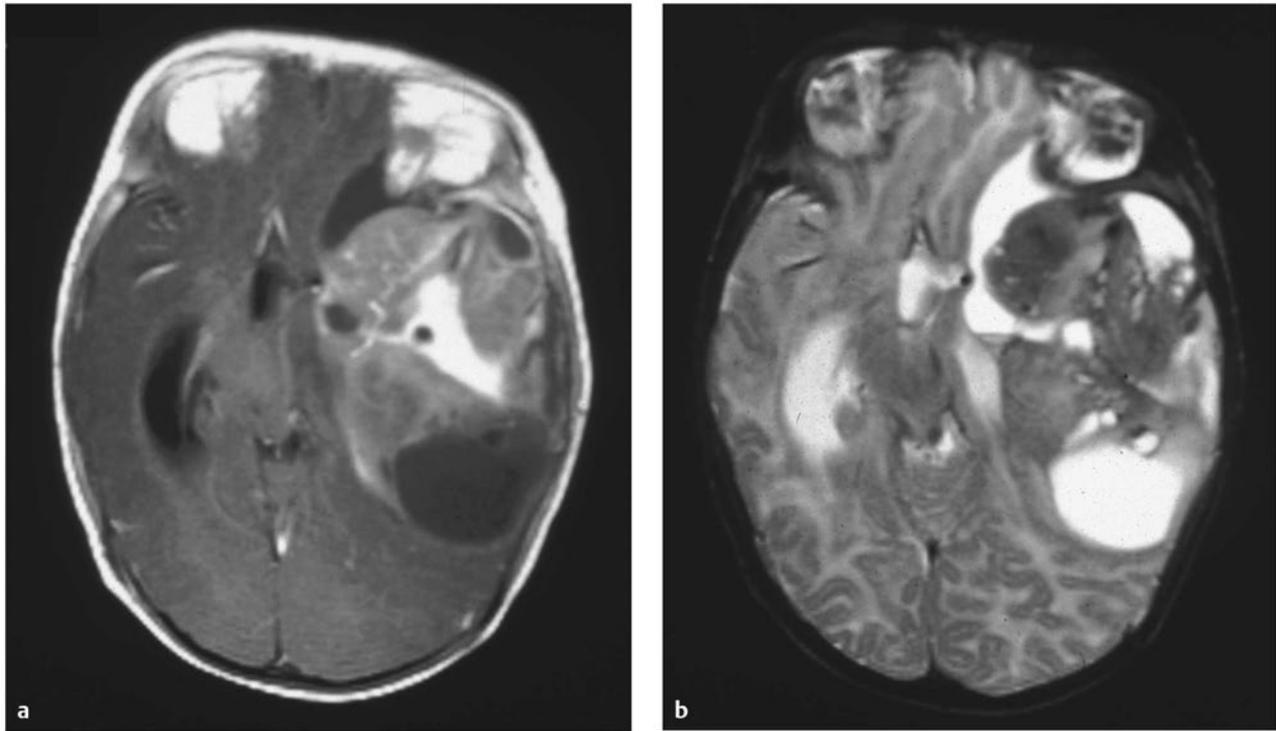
Anaplastic astrocytoma. (a) Axial T1-weighted magnetic resonance image with contrast administration and (b) T2-weighted sequence in a 3-month-old boy who presented with failure to thrive and a divergent macrocrania. A very large mass with macroscopic cystic changes is seen in this anaplastic astrocytoma (World Health Organization grade III) of the left cerebral hemisphere. In addition to the severe mass effect, the tumor has caused ventriculomegaly, which accounts for a substantial component of the hemispheric volume.
